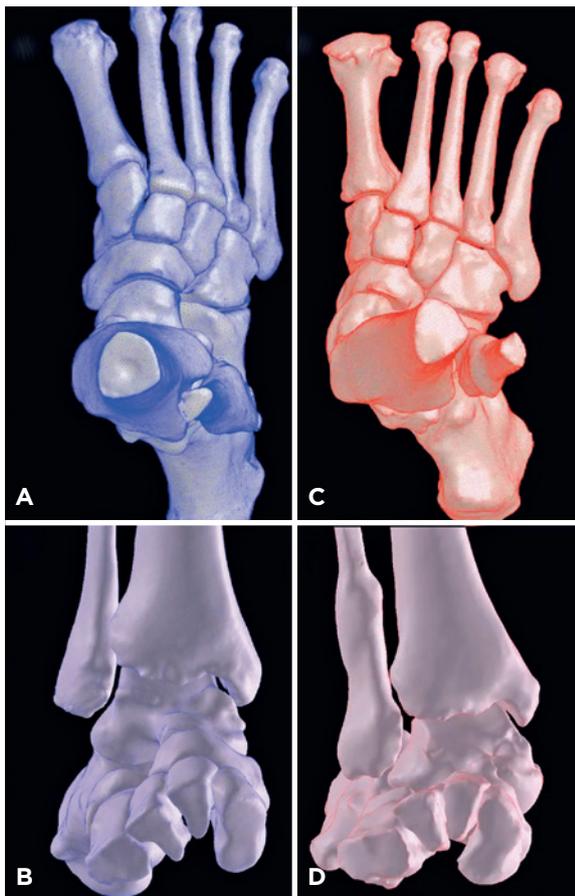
Three-dimensional weight-bearing computed tomography reconstruction from a patient with neutral/physiological alignment (blue; A and B) and progressive collapsing foot deformity (red; C and D). Axial (A and C) and coronal (B and D) views show signs of peritalar subluxation, such as external rotation and eversion of the subtalar joint, midtarsal external rotation and translation, and subtalar and subfibular impingement.
